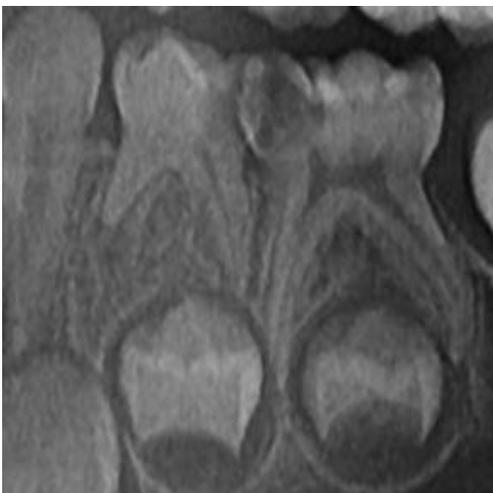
Radiographic appearance of external apical root resorption in mesial root of 7.4
